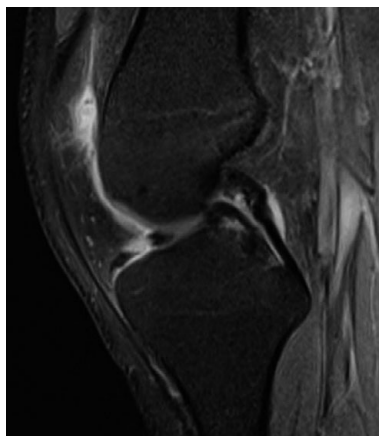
MRI scan knee sagittal T2 view
